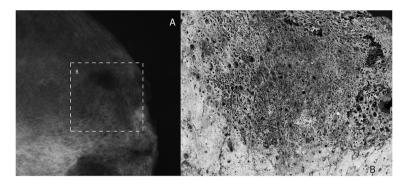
Erosive lesions at the ilium of the left coxa (case 3). A: X-ray showing a radiolucent region indicative of such lesions. B: Detail of the erosive lesion surrounded by lamellar PNBF at the insertion area for gluteus medius.
